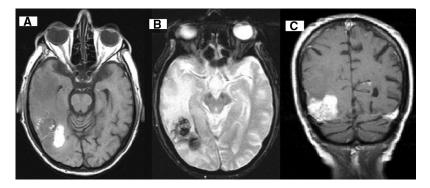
Axial (A) FLAIR, (B) FLASH 2d, (C) Coronal postcontrast T1W. A 71-year-old neurologically asymptomatic man with adenocarcinoma of the left lung in stage IV with multiple hemorrhagic metastases largest in the right temporo-occipital region measuring 3.9 cm.
